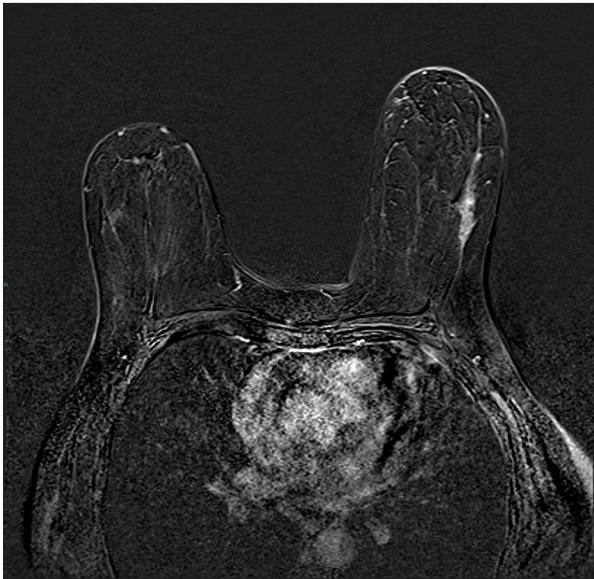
Appearance of the ductal carcinoma in situ on magnetic resonance imaging (MRI). The axial digital subtraction dynamic (MRI) sequence after an intravenous gadolinium injection showed a 33-mm non-mass contrast enhancement characterized by a regional enhancement distribution in the lower external quadrant of the left breast.
